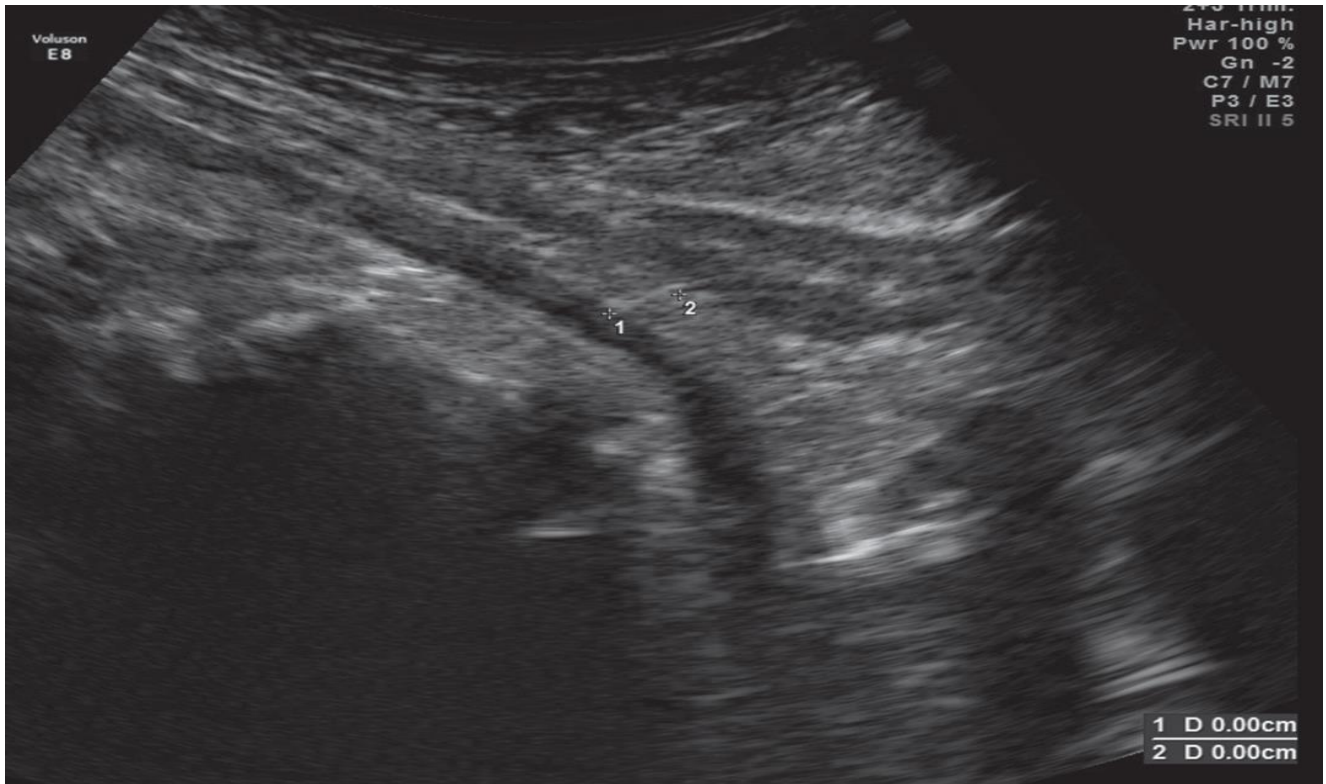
shows Third-trimester trans-abdominal ultrasound images of a patient with a history of Caesarean section, showing a sliding sign. (a) The Starting point is before the patient is asked to breathe; point 1 is on the uterine serosa, and point 2 is on the muscle fascia
